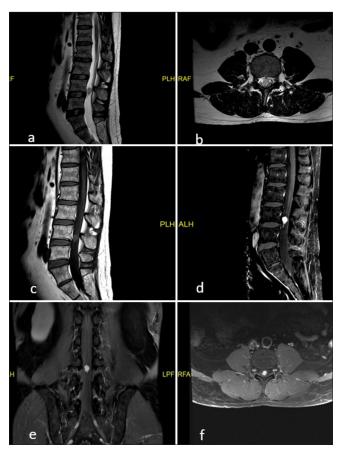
(a and b) Magnetic resonance imaging of the lumbar spine with sagittal, axial plane T2-weighted pulse sequences; (c and d) Sagittal T1 weighted (T1W) pulse sequence before and after injection, (e and f) coronal and axial T1W image after injection. A space-occupying lesion of a nerve root in cauda equina at the L4–L5 level, oval-shaped, well-defined margin, showing mildly increased signal on T2-weighted sequence with a surrounding hemosiderin rim, mildly increased signal on precontrast T1W pulse sequence, and contrast enhancement on post-contrast T1-weighted sequences. The lesion creates a mass effect, displacing adjacent cauda equina nerve roots.
